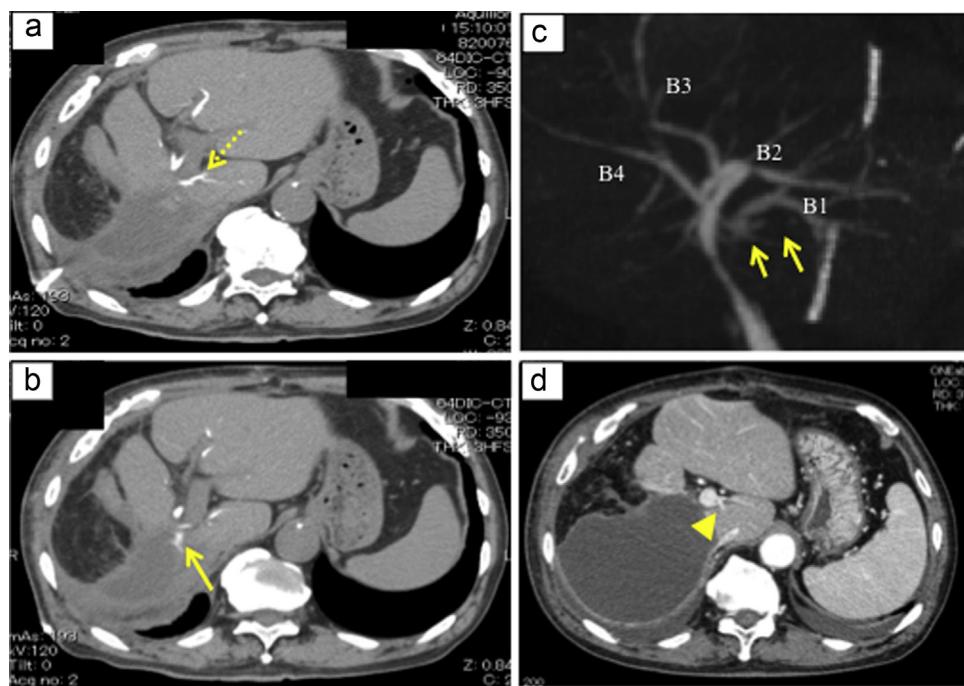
Findings of DIC-CT (a–c) and enhanced CT of portal phase (d). The DIC-CT showed the bile duct from the Spiegel lobe (dotted arrow) and the bile leakage from Spiegel lobe (arrows). The enhanced CT showed the portal veins to Spiegel lobe (arrowhead). The portal veins in the Spiegel lobe branched from the left first branch.
